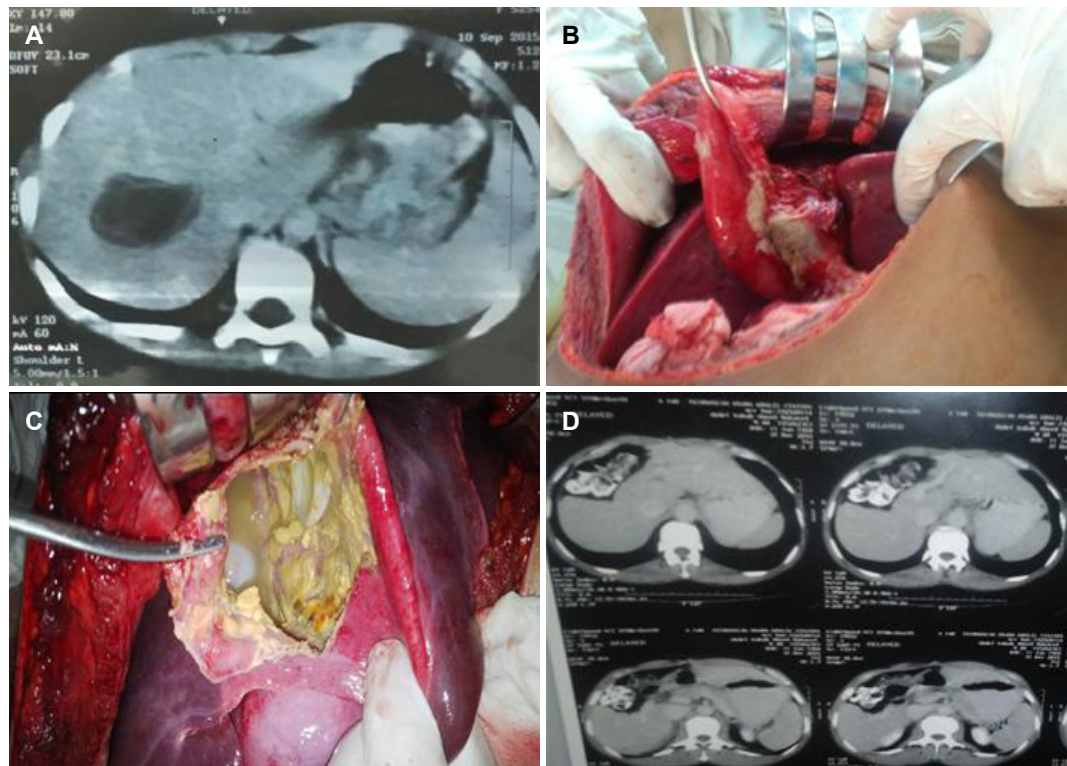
A: Intra-parenchymal hydatid cyst in female 9 years old; B: ruptured hydatid cyst in 17 years male; C: huge central hydatid cyst in 45 years male; D: CT 2 years after huge central hydatid removal
